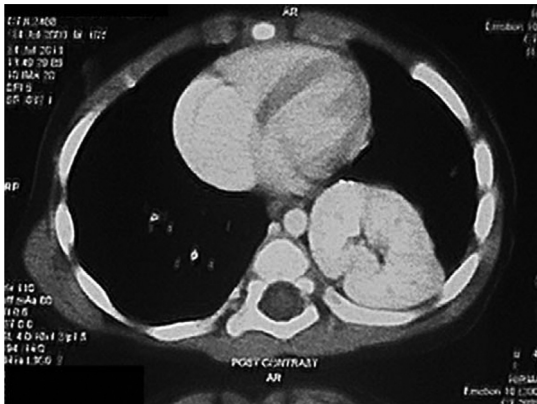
Case 1 – thorax CT showing isolated herniation of the kidney in the left thoracic cavity.
